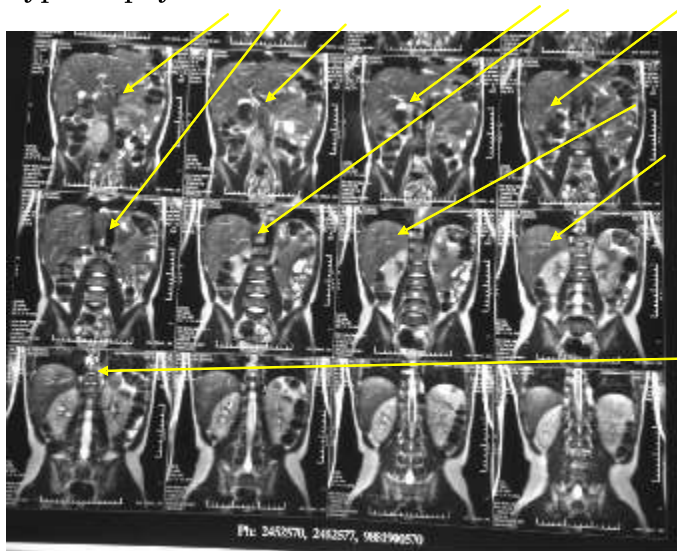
Magnetic Resonance Imaging of the Child's abdomen showing the tumour mass(arrows) in serial films(photographs taken in an Indian Hospital)
